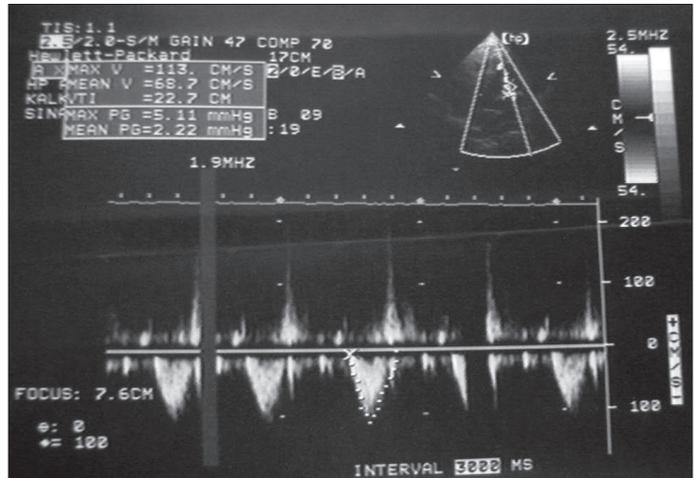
Transthoracic echocardiography view of normal pulmonary arterial pressure and structure of pulmonary valve
